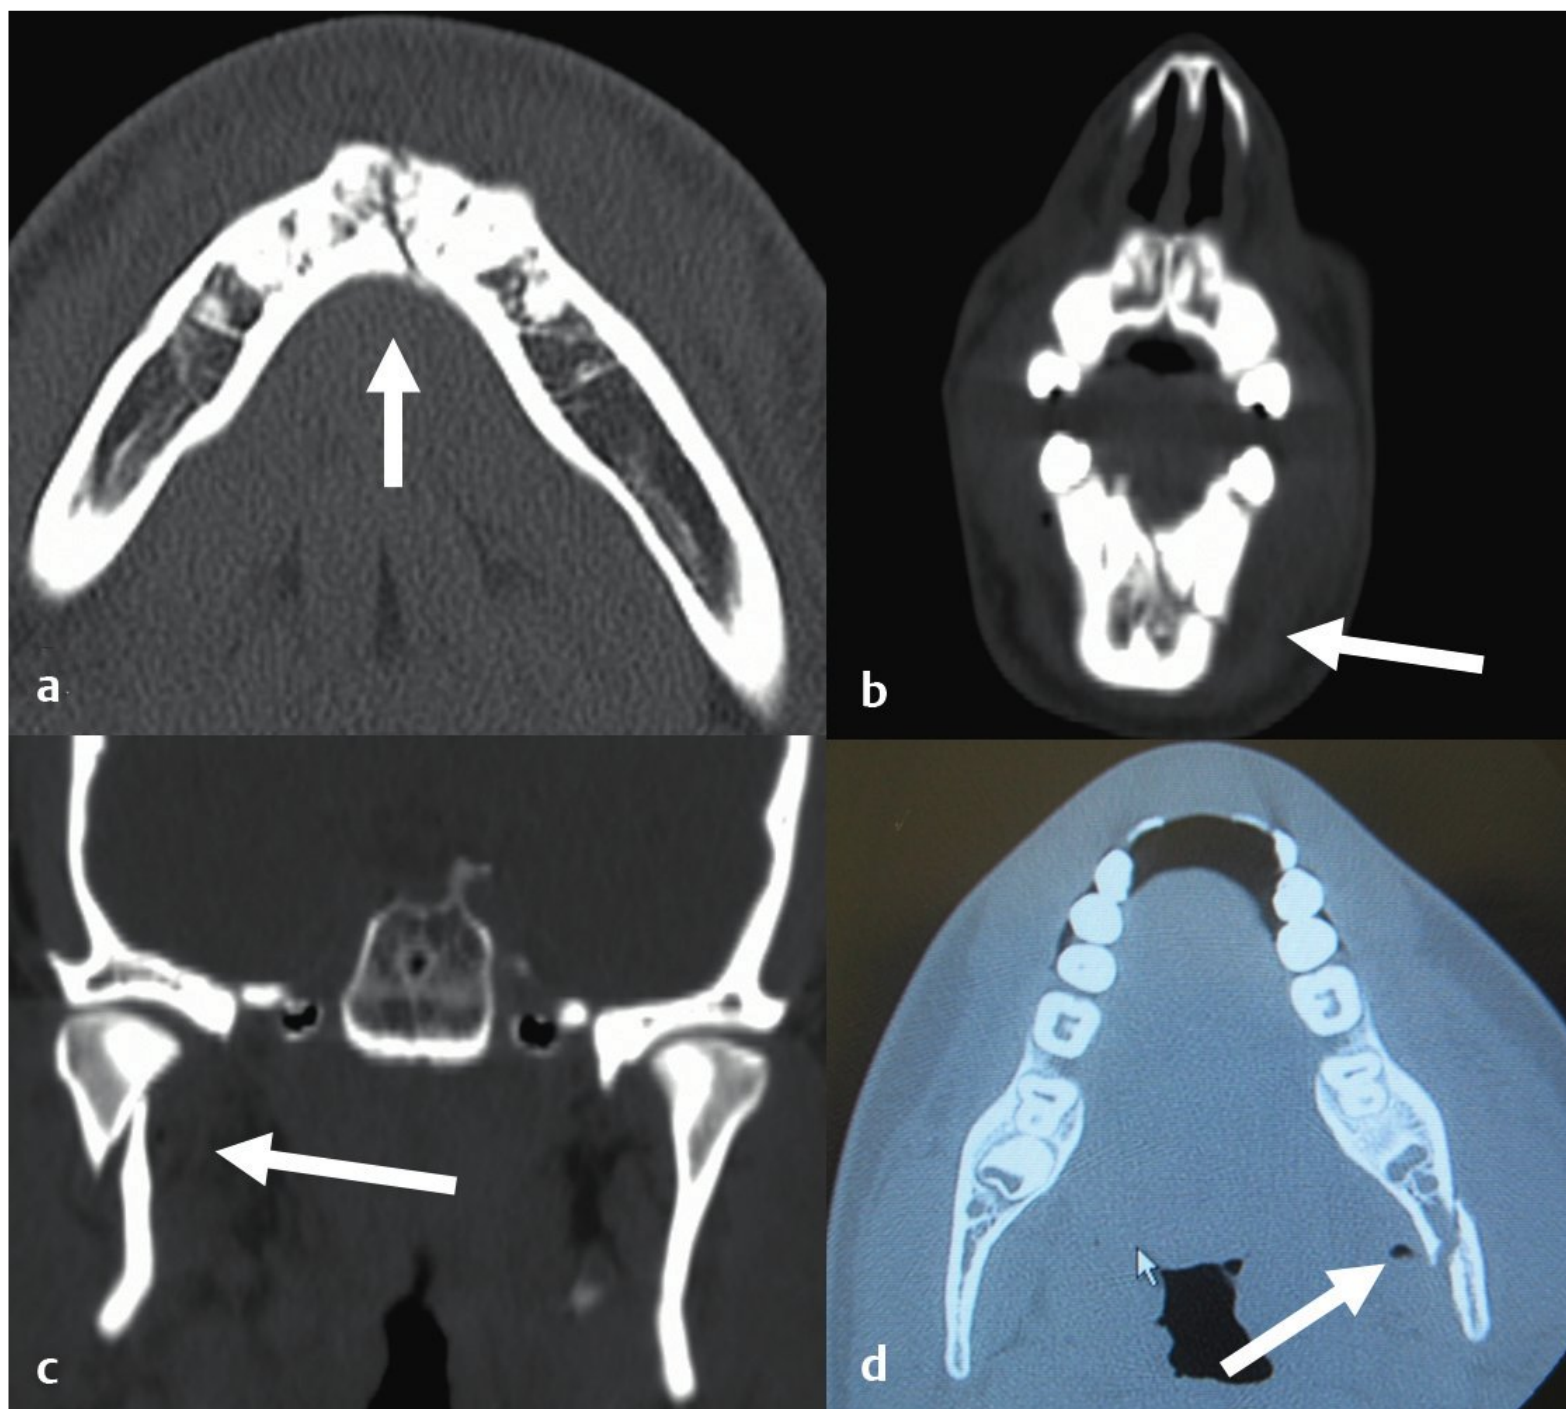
(a) CT evaluation of a fracture of the symphysis. (b) Evaluation of the parasymphyseal fracture by coronal CT. (c) CT coronal scan of the same patient as in Fig. 11.4 demonstrating a subcondylar fracture not easily seen on the Panorex radiograph. (d) CT evaluation of a fracture of the angle.
